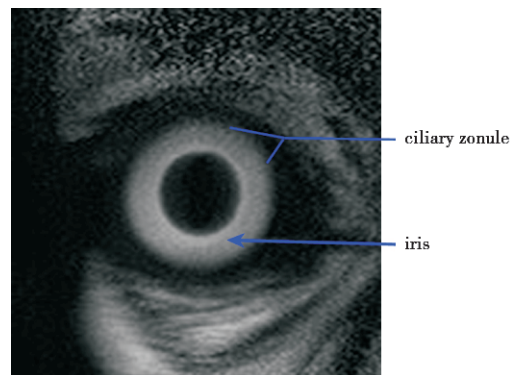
Coronal SSh-TSE sequence T₂WI HR-MR image. The layers of the ocular wall fine anatomy are depicted.
